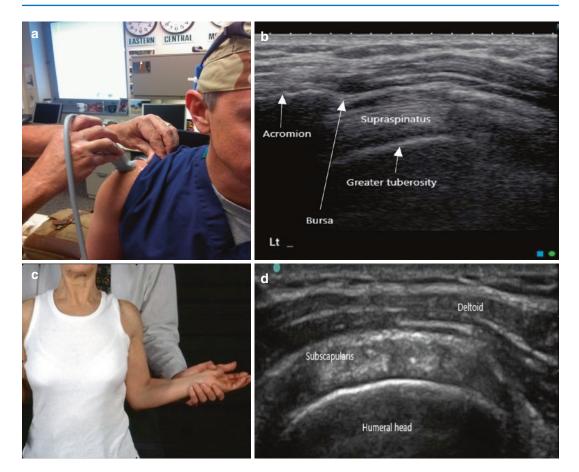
(a–d) Ultrasonographic evaluation of the rotator cuff complex. Superior (a, b) and anterior (c, d) placement of the transducer and corresponding ultrasound view
